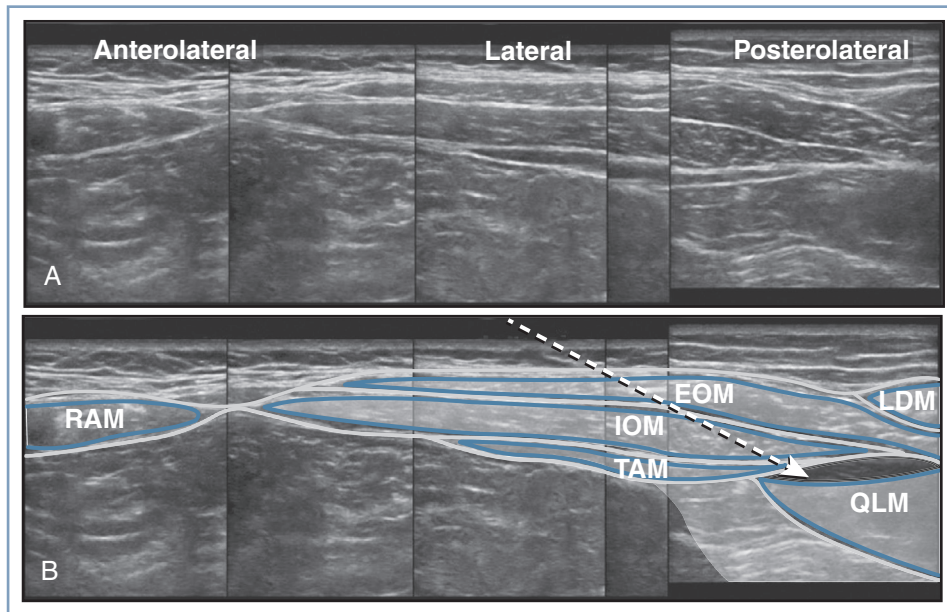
Ultrasonographic image of the quadratus lumborum block-1 (QLB-1). (A) With the patient in the supine position, the three muscle layers of the abdomen and the quadratus lumborum muscle are visualized with a high-frequency linear probe. (B) The outlines the abdominal fascial planes and the infiltration site for the QLB-1 between the quadratus lumborum muscle and the medial layer of the thoracolumbar fascia are clearly outlined. The *broken arrow* shows the needle path and point of injection. *EOM*, External oblique muscle; *IOM*, internal oblique muscle; *LDM*, latissimus dorsi muscle; *QLM*, quadratus lumborum muscle; *RAM*, rectus abdominus muscle; *TAM*, transversus abdominus muscle. (Modified from Murouchi T, Iwasaki S, Yamakage M. Quadratus lumborum block: analgesic effects and chronological ropivacaine concentrations after laparoscopic surgery. *Reg Anesth Pain Med*. 2016;41:146–150.)
